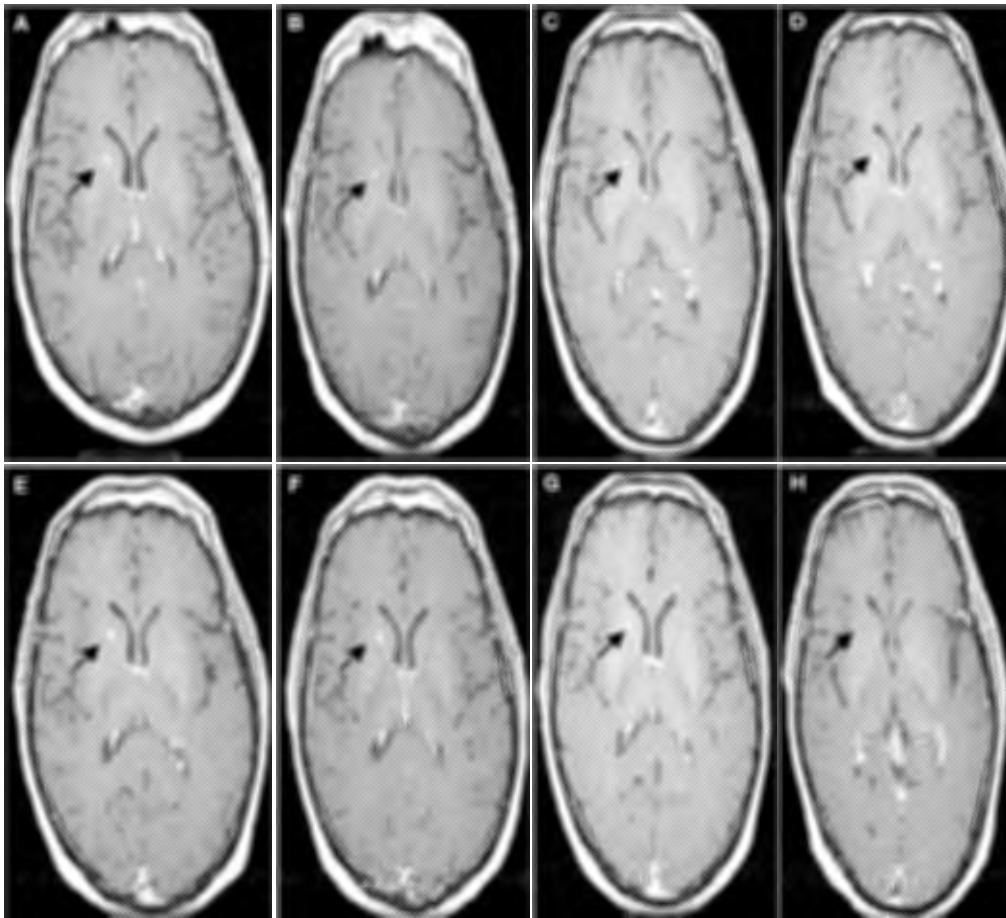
MRI scans. The tiny lesion (arrows) was initially suspected to be a brain metastasis, but it remained stable during a 21-month period in a patient with melanoma. A, baseline; B, 1 mo; C, 3 mo; D, 5 mo; E, 8 mo; F, 11 mo; G, 14 mo; H, 21 mo.
